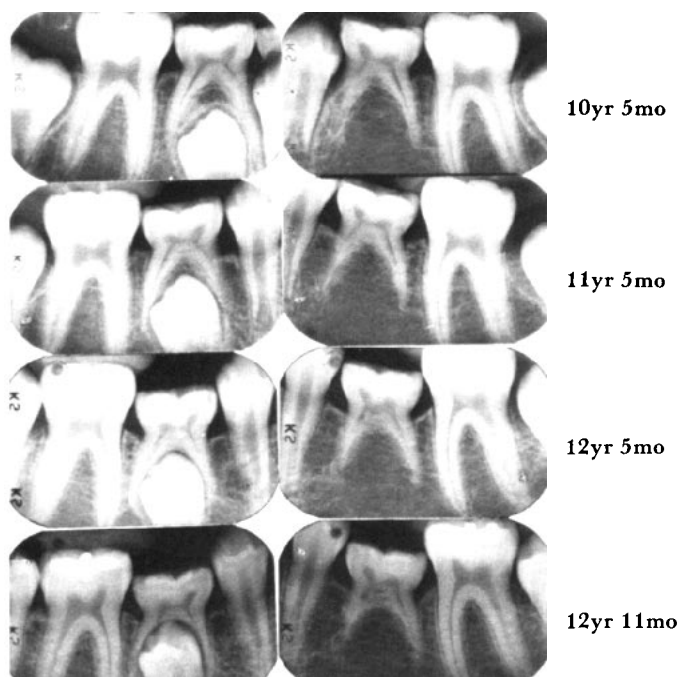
Periapical radiographs of a boy from 10yr 5mo to 12yr 11mo of age. Note the root resorption and progressive infraocclusion on both sides. Root resorption for the deciduous molar with no successor was 1.2mm mesially and 0.1mm distally during the 2.5 year observation period. The infraoccluded deciduous molar with a permanent successor exfoliated normally one year after the last radiograph, at 13yr 11mo of age.
